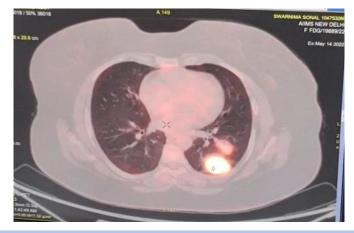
PET CT WB showing two left lower lobe lung mass
